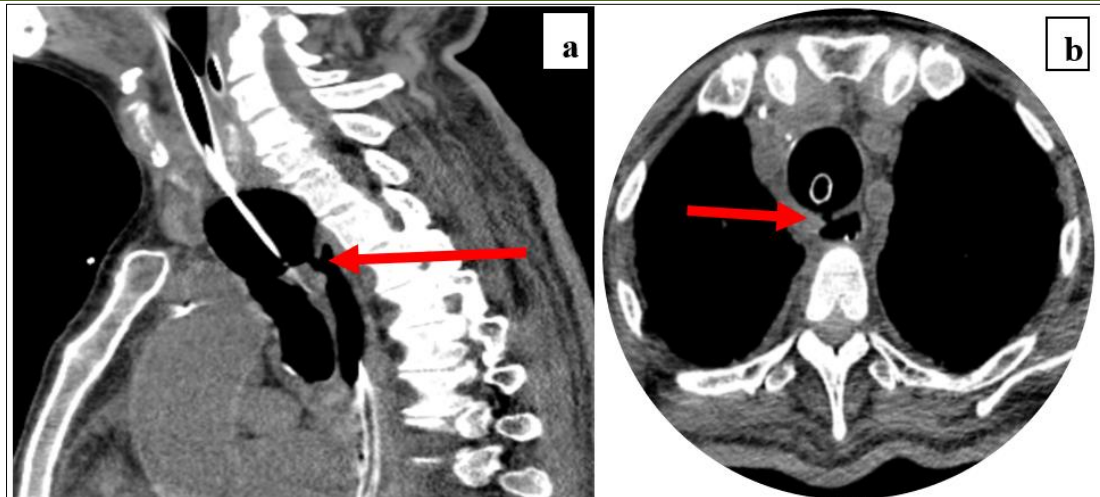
CT scan in sagittal and axial views of the cervicothoracic junction demonstrating an esophagotracheal fistula at the T3 level (red arrow)
